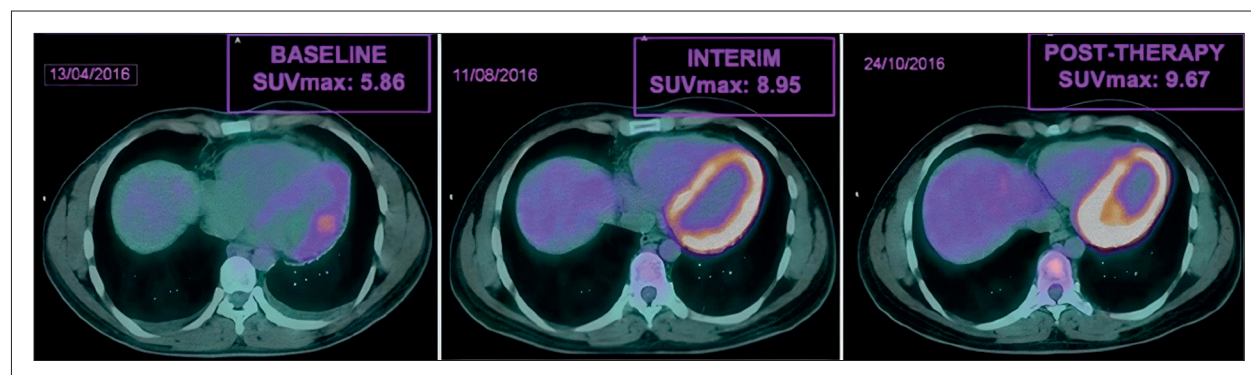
Case example - LV SUVmax in Baseline (5.86), Interim (8.95 / 52.73% percentage increase from baseline) and Post-therapy PET/CT (9.67 / 65.02% percentage increase from baseline). LV: Left Ventricle; PET/CT: Positron emission tomography associated with computed tomography scans; SUV: Standard Uptake Value; SUVmax: Maximum SUV.
